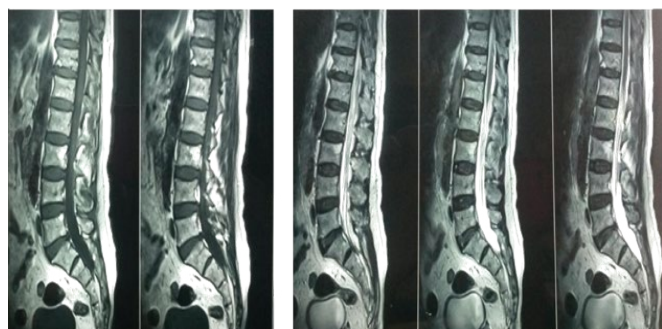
Normal Spinal MRI T1 weighted SAG T1 and Normal Spinal MRI: T2 weighted SAG T2.
